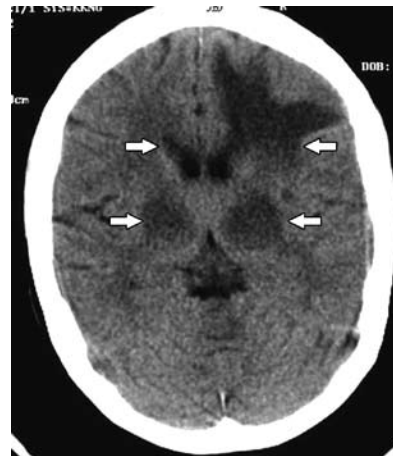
Computed tomography of a young HIV positive patient with CNS toxoplasmosis showing hypodense areas in the basal ganglia and frontal lobes with surrounding areas.
